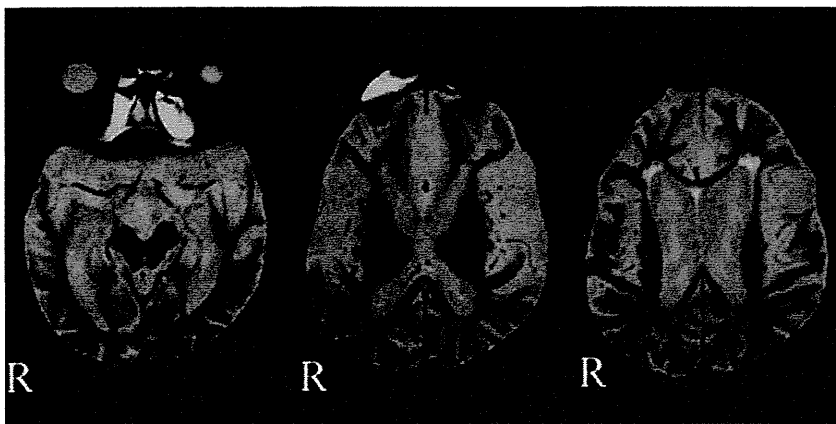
Cranial MRI (axial, T2-weighted image), showing a slight decrease in signal intensity in the globus pallidus and substantia nigra and severe atrophy of the frontal, temporal lobes, and brainstem. (R, right side).
